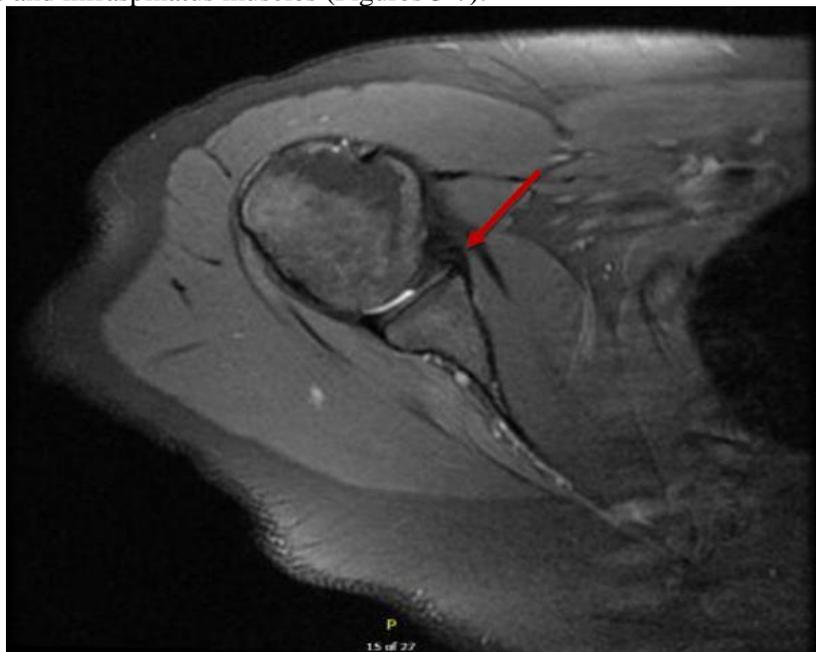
MRI of Right shoulder (axial) showing a SLAP lesion.
